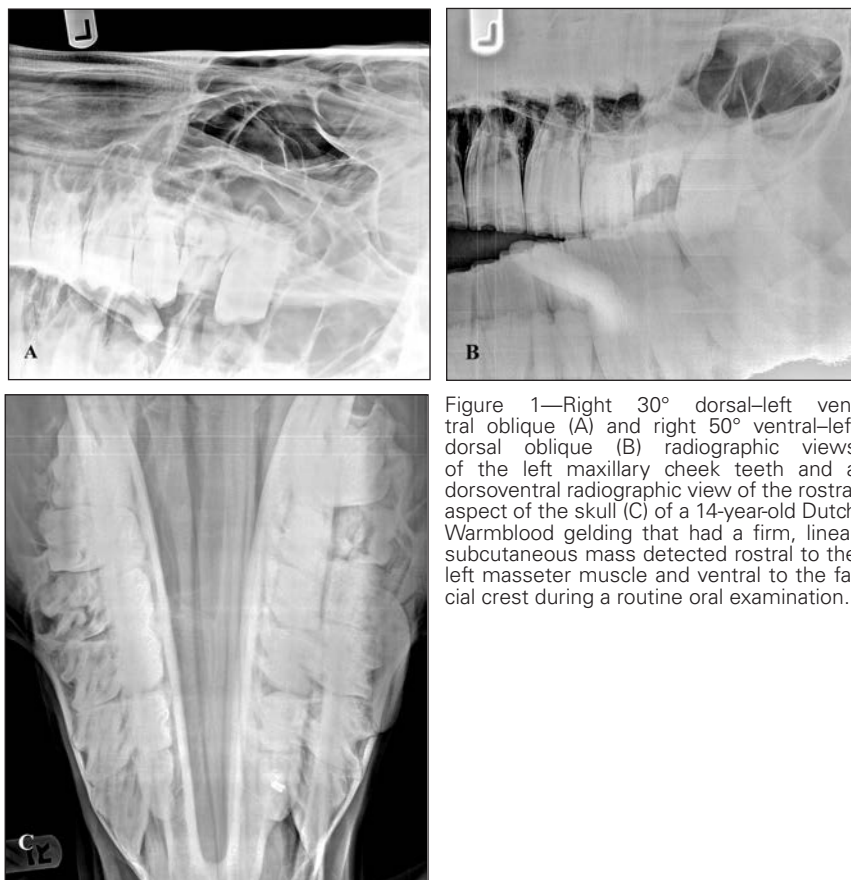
Right 30° dorsal–left ventral oblique (A) and right 50° ventral–left dorsal oblique (B) radiographic views of the left maxillary cheek teeth and a dorsoventral radiographic view of the rostral aspect of the skull (C) of a 14-year-old Dutch Warmblood gelding that had a firm, linear subcutaneous mass detected rostral to the left masseter muscle and ventral to the facial crest during a routine oral examination.
